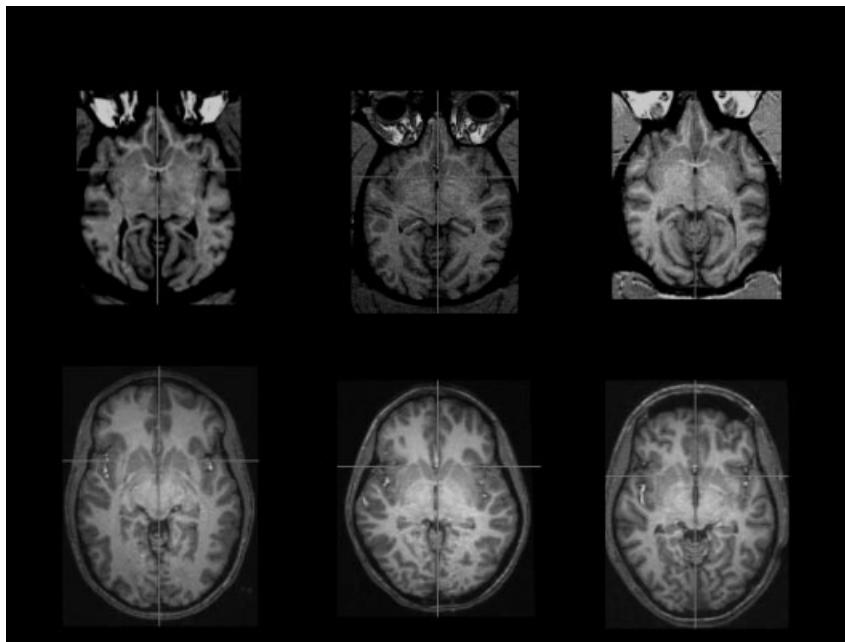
Orbitofrontal cortex in humans and chimpanzees. Horizontal MRI sections through the brains of three chimpanzees (top) and three humans (bottom) showing the difference in orbitofrontal white matter volume. Human images have been reduced to the size of chimpanzee images for the purpose of comparing the relative size of OFC white matter.
